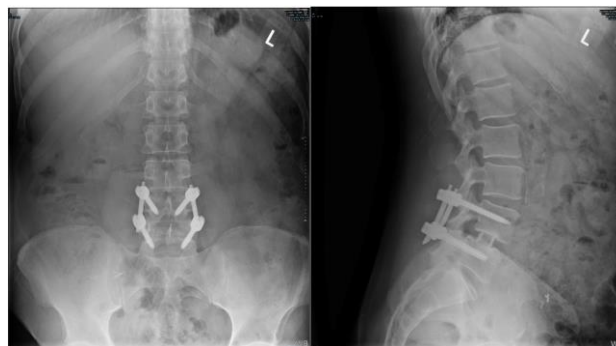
On 3/19/21, 4 views of the lumbar spine were obtained on X-ray, including AP, lateral, flexion, and extension. There is an L4-L5 fusion with interbody and no signs of hardware failure.
